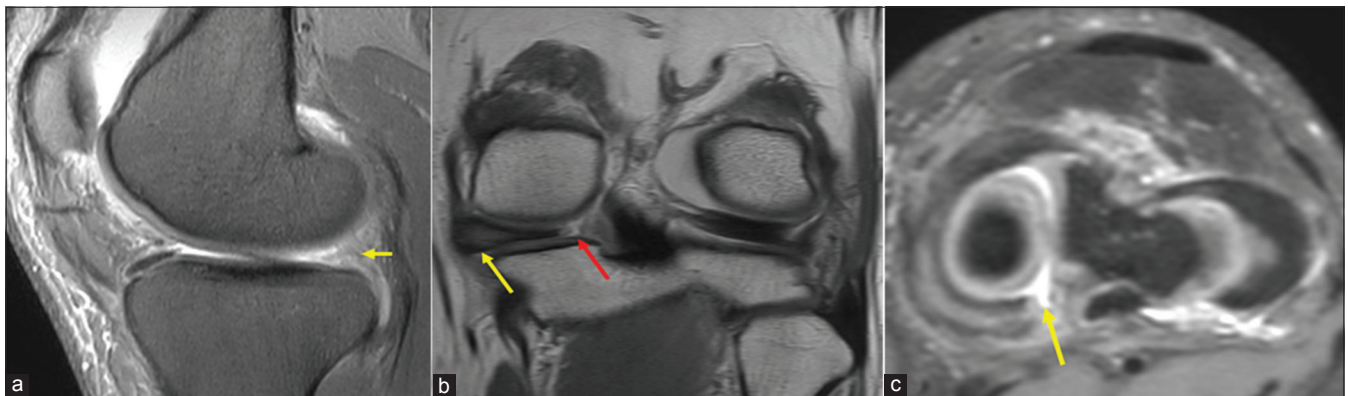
Magnetic resonance imaging diagnosis of medial meniscus posterior root tear – (a) The “ghost meniscus” sign, i.e., absent posterior horn of medial meniscus (yellow arrow) in Proton Density Fat Saturated [PDFS] sagittal section. (b) T1-weighted coronal section showing the site of root tear (red arrow) and extrusion of meniscal tissue outside the joint line (yellow arrow). (c) Axial section across the meniscus demonstrating the site of tear (yellow arrow)
